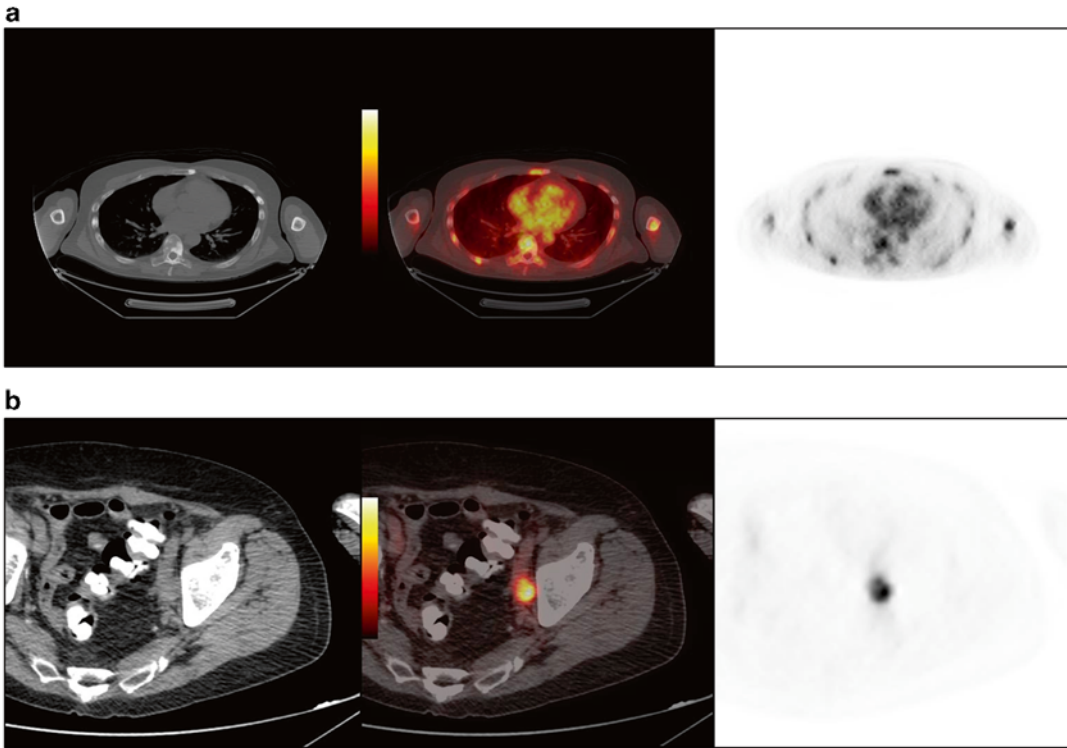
PSMA-based ^{18}F -DCFBC PET/CT demonstrates (a) widespread bone metastases and “superscan” bone scan in a 62-year-old with metastatic CRPC, and (b)
